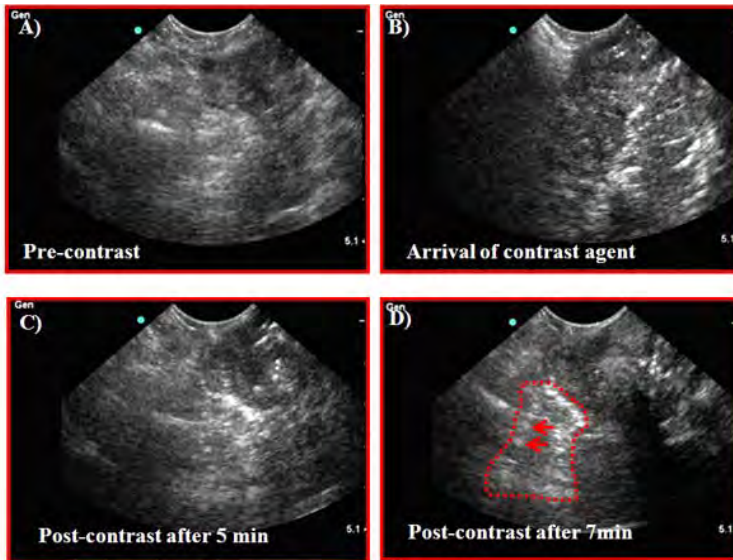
Detection of ovarian tumors by $\alpha_v\beta_3$ -integrins targeted contrast enhanced ultrasound (CE-US) molecular imaging. A) Pre-contrast gray scale ultrasound image of a hen ovary. Intensity of the signals from the tissue is very low and the presence of any solid mass is not decisive. B) Gray scale CE-US image of the same ovary at the arrival of contrast agent (CA). Compared to pre-contrast, remarkable increase in signal intensity is seen (appears like a white ring). But the binding of CA is not yet specific. C) Gray scale CE-US image of the same ovary 5 minutes after the injection of CA. With the washing out of unbound CA, bindings of CA are seen to be more specific. D) Gray scale CE-US image of the same ovary 10min after the injection of CA showing specific binding of CA. Regions of interest containing solid tissue mass bounded by targeted CA is indicated as red dotted circle. Arrows indicate the example of specific bindings of CA.
